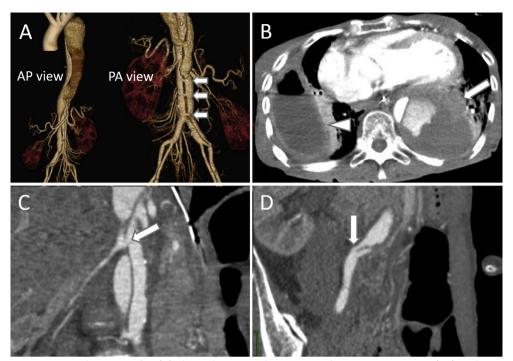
Pre-operative computed tomography. (A) Three dimensional images, in the antero—posterior (AP) and postero—anterior (PA) views, showed a post-dissection thoraco-abdominal aortic aneurysm. The arrows indicate re-entry tears at the detached right lumbar arteries in the PA view. (B) A haematoma around a dilated descending false lumen indicates rupture (arrow). In the right thorax, there was a large chronic empyema (arrowhead). (C) A multiplanar reconstruction image showed a large re-entry tear at the detached right renal artery ostium (arrow). (D) Another major re-entry tear at the right iliac bifurcation (arrow).
